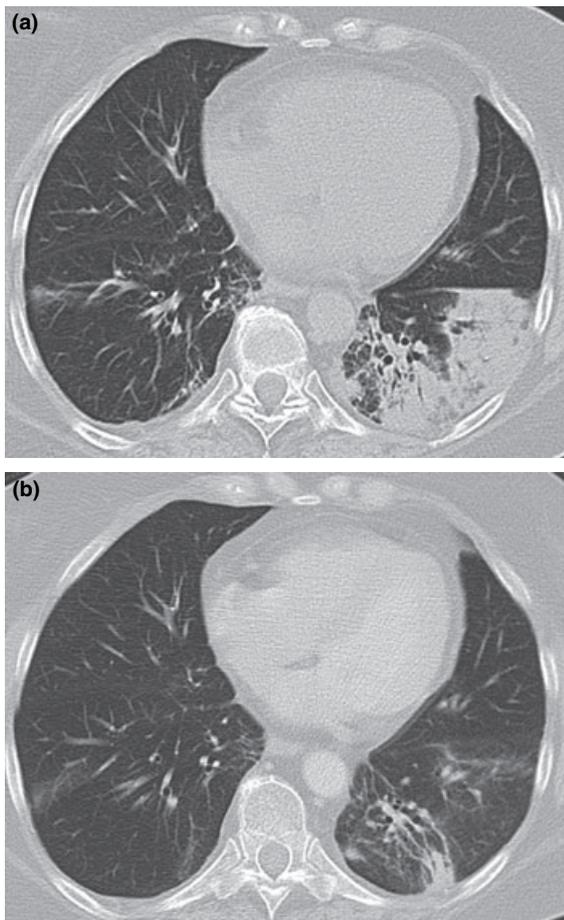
CT Scan at time of diagnosis (a) revealed infiltrates in the left lower lung. Follow-up CT-Scan after 1 month of everolimus discontinuation (b) showed marked regression of infiltrates.
